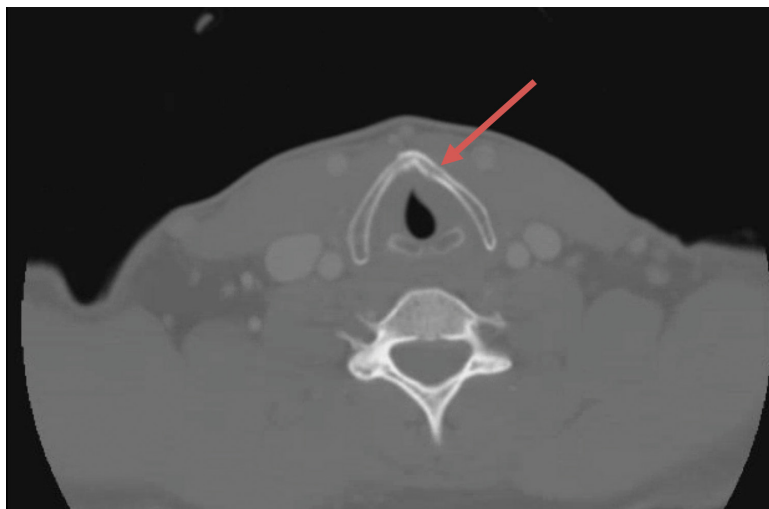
Computed tomography image of the soft-tissue neck with contrast showing a minimally displaced fracture of the left thyroid cartilage with soft-tissue swelling with minimal narrowing of the subglottic trachea. No abnormal enhancement or abnormal fluid collection, and no evidence of vocal cord abnormality or asymmetry.
